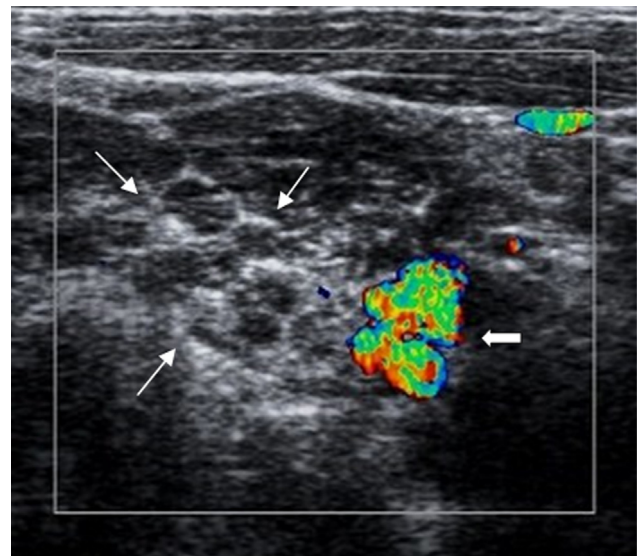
US image of right supraclavicular region with color Doppler. Thin arrows indicate brachial plexus, and thick arrow indicates subclavian artery.
